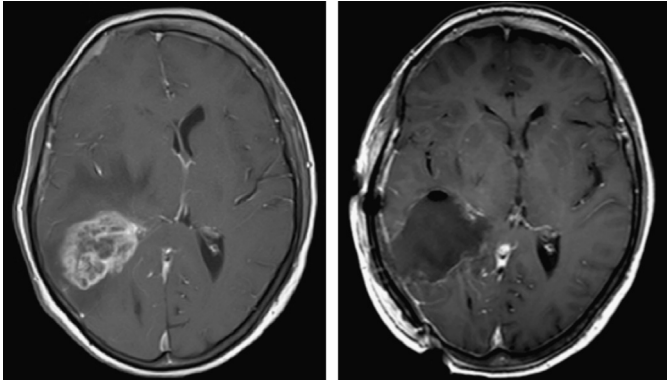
Pre-operative MRI showing a high-grade glioma located in associative areas and ventricular crossroad. On the right, early post-operative control (<72 h) with no more contrast enhancing tumour.
